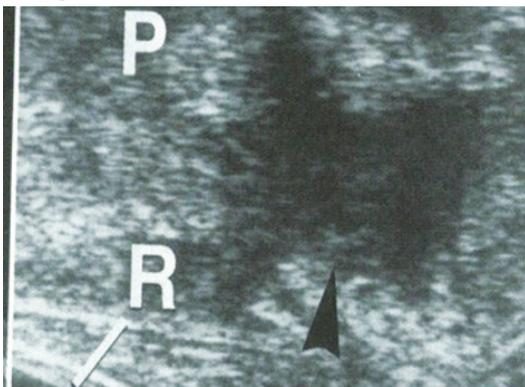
Ultrasonography of the « sphincter hourglass »
